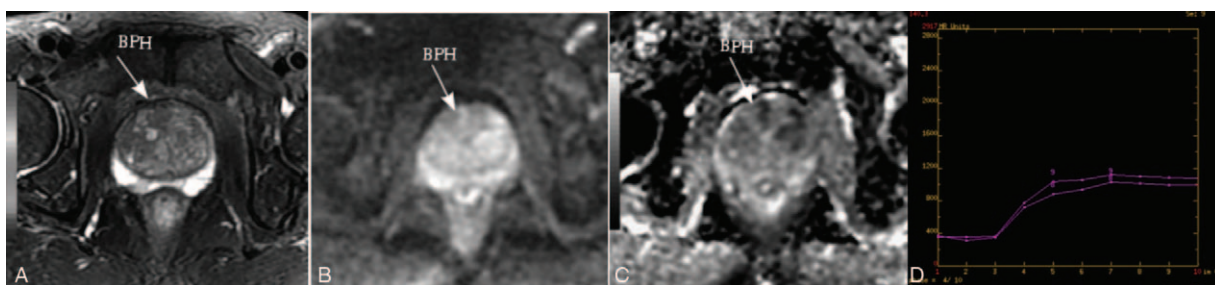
Magnetic resonance imaging results of the central region of benign prostatic hyperplasia (BPH).
